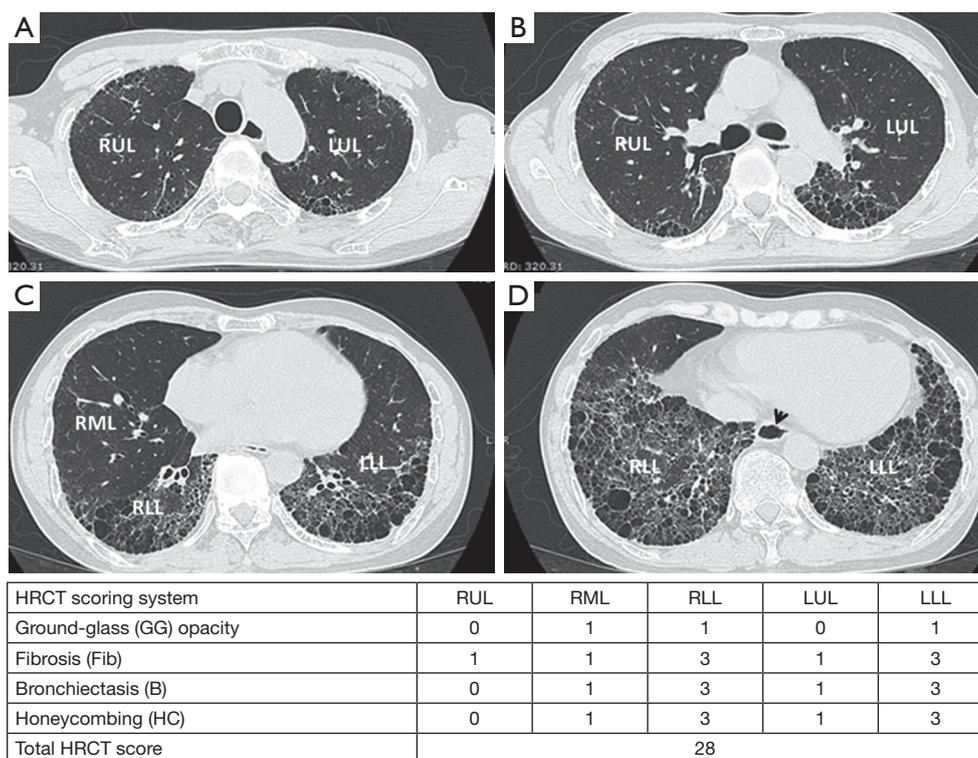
Four high-resolution computed tomography (HRCT) images in a 48-year-old man with dcSSc at level of aortic arch (A); carina (B); inferior pulmonary vein (C) and lung base (D) reveals peripheral diffuse coarse reticulation (Fib), honeycombing (HC) and traction bronchiectasis (B) in both lower lobes, and minimal ground glass (GG) opacity at RML, which compatible with usual nonspecific interstitial pneumonitis (UIP) pattern. There was esophageal dilatation (arrow head).
